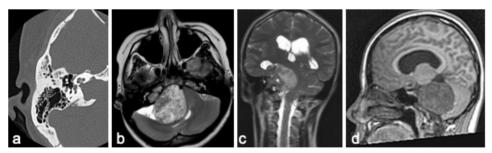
Preoperative imaging of patient 21 with a very large vestibular schwannoma and a contracted mastoid process. A. Axial CT scan of the right mastoid. B. Axial T2 MRI. C. Coronal T2 MRI. D. Sagittal T1 MRI, no contrast
